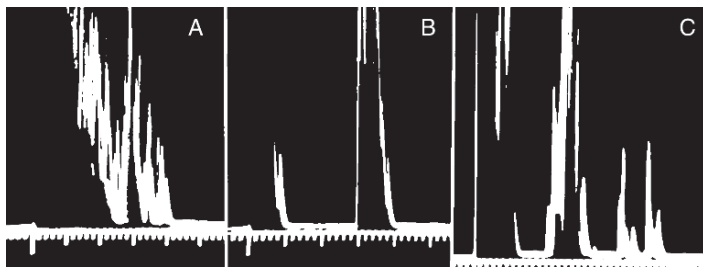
A-mode ultrasound images. a. shows an A-mode ultrasound image of a solid thyroid nodule. Scattered echoes are present from throughout the nodule. b. shows the image from a cystic nodule. The initial reflection is from the proximal wall of the cyst, with no significant signal reflected by the cyst fluid. The second reflection originates from the posterior wall. c. shows the A-mode image from a complex nodule with solid and cystic components
